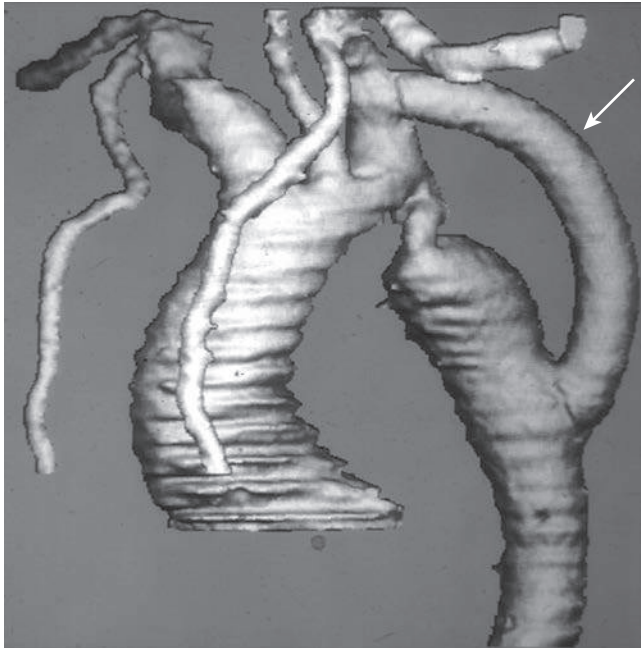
Spiral computed tomography image of an adult with severe coarctation after implantation of an extraanatomic tube graft (arrow) between the left subclavian artery and the descending aorta.
